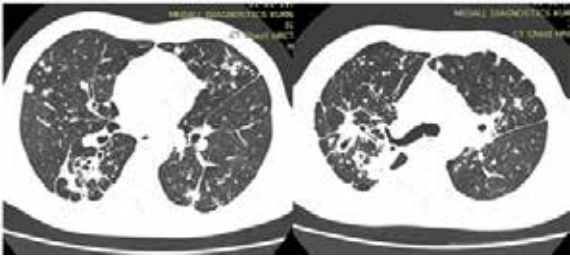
(a) and (b) Axial HRCT images of a single patient aged 45yrs on treatment since 5days showing multiple parenchymal nodules of 5-10mm in right middle lobe and left lingular segments. Bilateral perihilar extensive fibrosis with traction bronchiectasis also noted.
